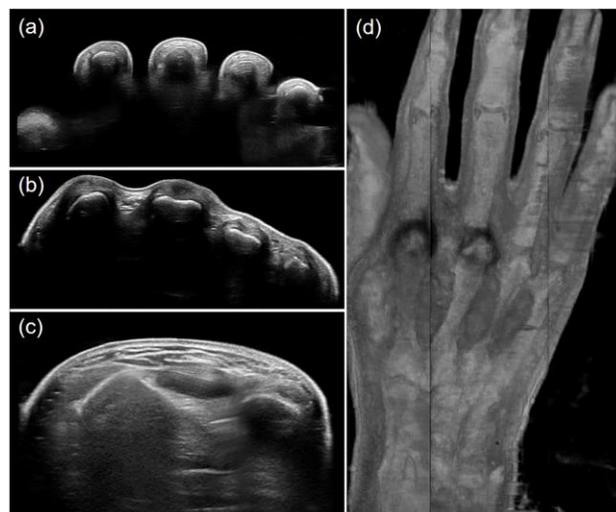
2D and 3D typical ultrasound images of the hand
